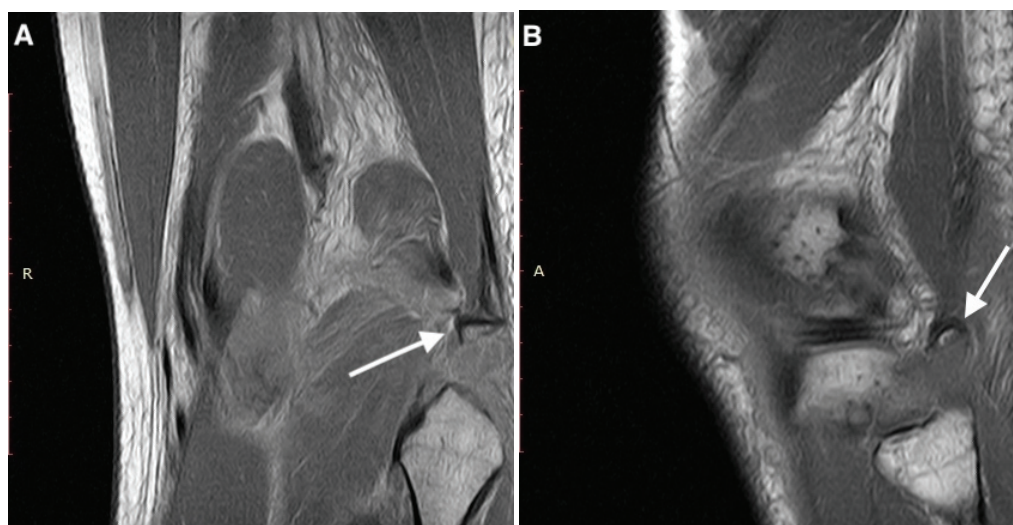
Preoperative magnetic resonance imaging (MRI): A) antero-posterior view of avulsed fragment; B) profile view of avulsed fragment.
